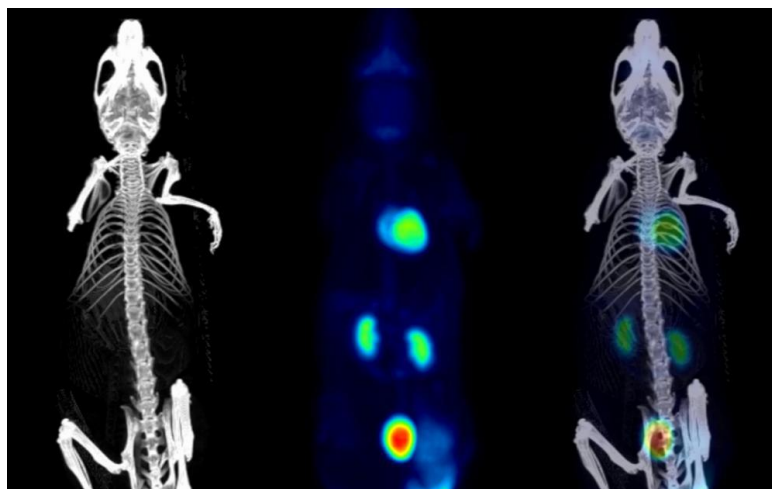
Hybrid PET – CT image slices. CT image (grey) provides an anatomical image whereas PET one (color) reveals the biomarker concentration (www.bruker.com).
